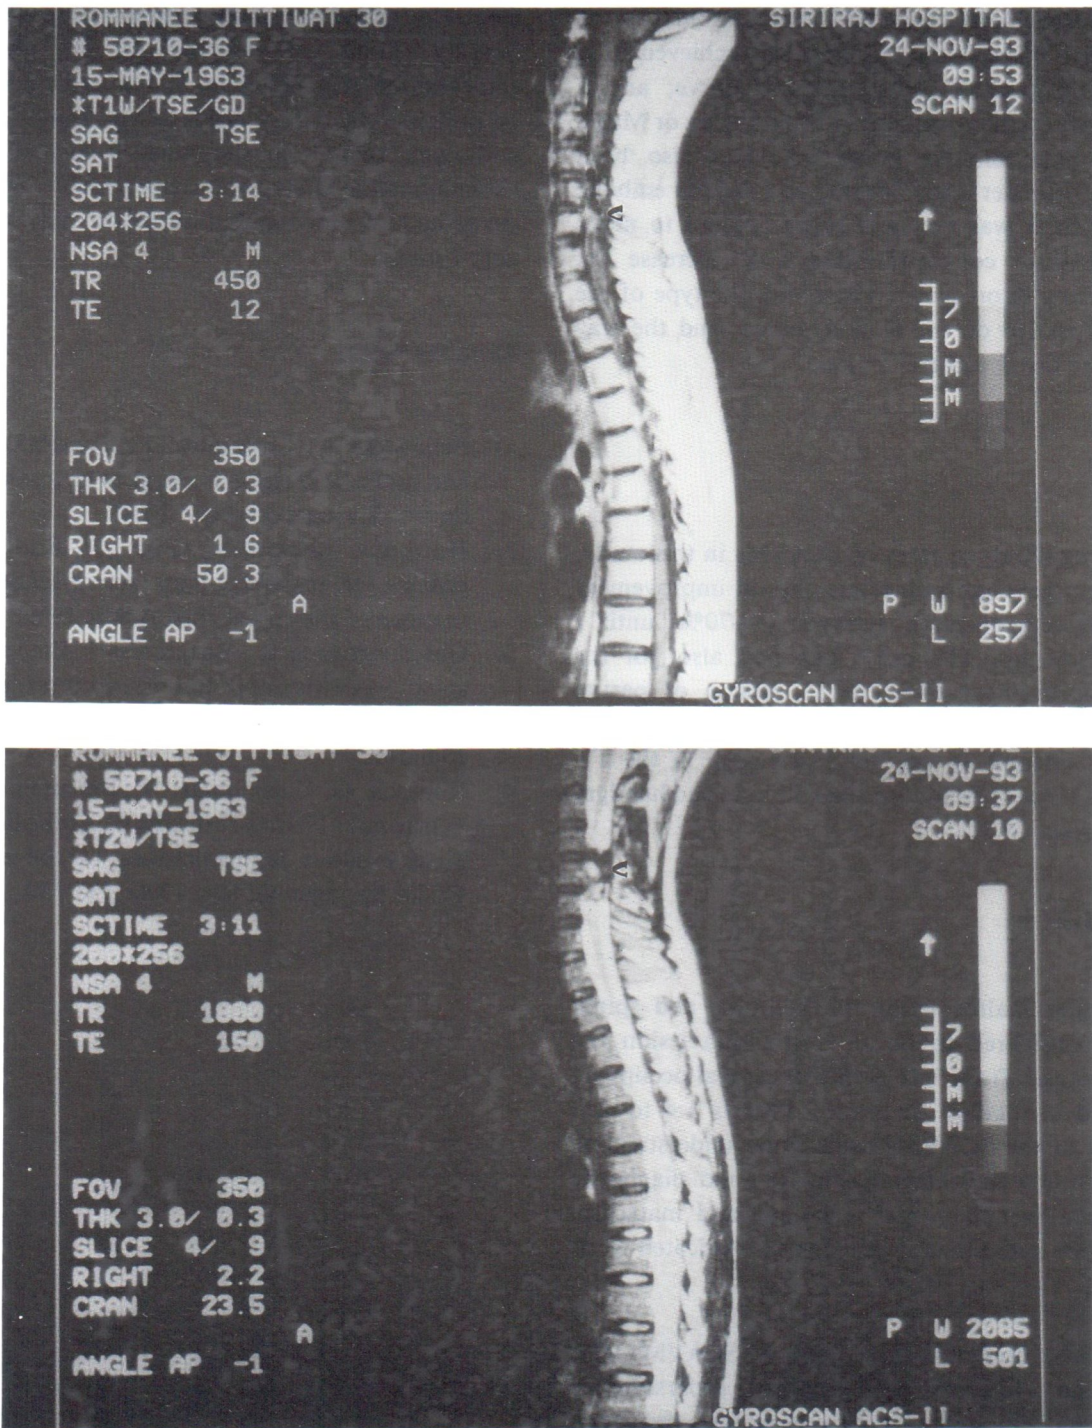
(A-B) Sagittal MRI T1W, T2W image showed hemorrhage within the AVM lesion at level of C 5-7 (arrow).
